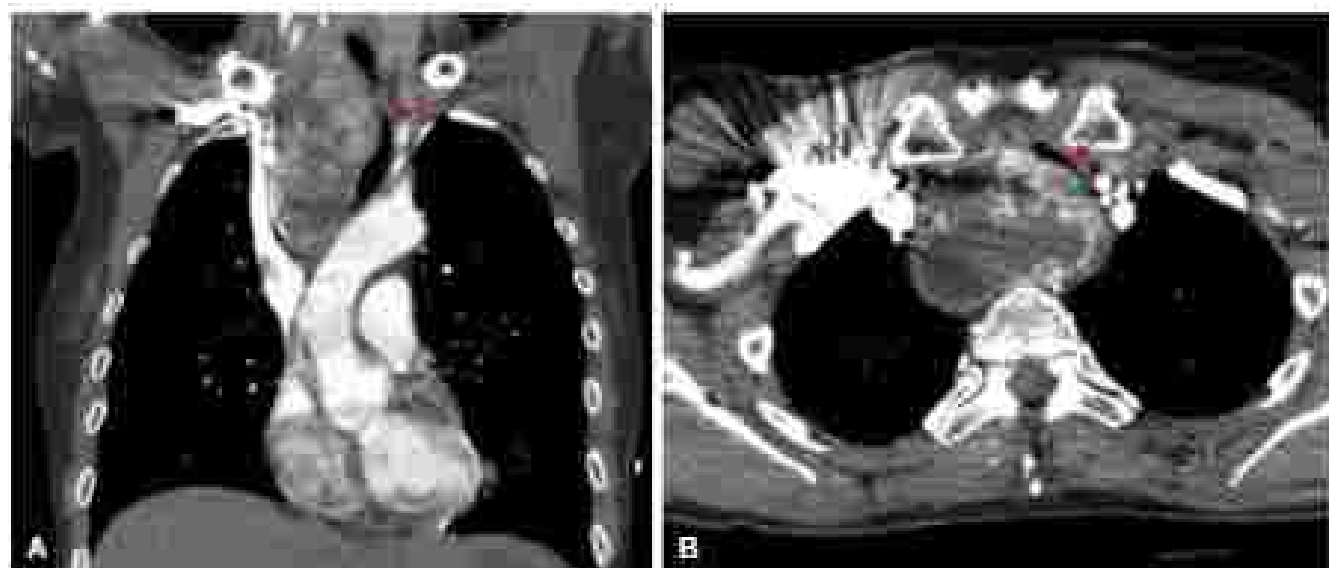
A 68-year-old woman with an incidentally found goiter during workup for dyspnea. On physical examination, the patient had no evidence of a palpable thyroid mass, but the (left) left respiratory vein (A) computed tomography scan revealed a large, septated subcarinal thyroid with tracheal deviation to the left (A) as well as tracheal narrowing at the level of the trachea (B).
